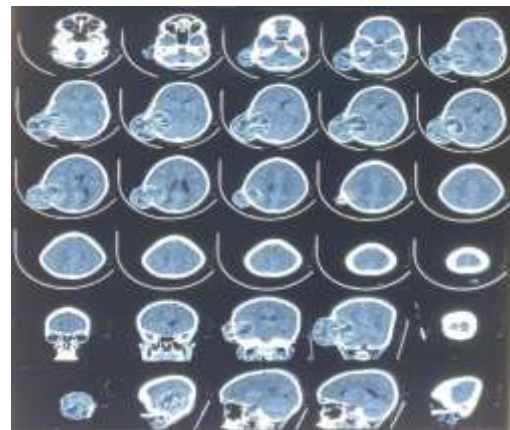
CT scan showing well defined lytic lesion, thin rim of reactive bone and fluid filled level is visible.
